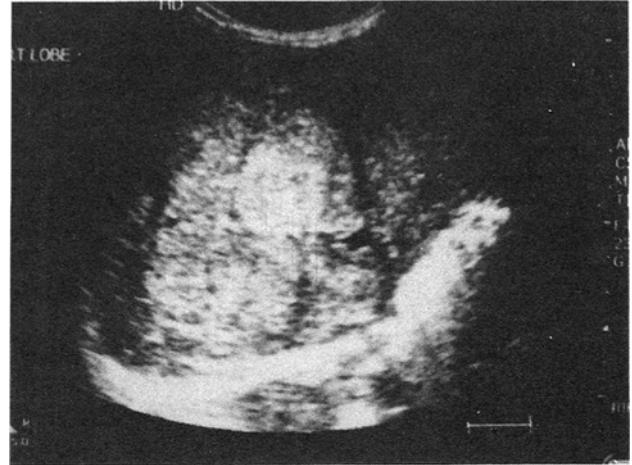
Longitudinal ultrasonogram shows predominantly hyperechoic heterogeneous echotexture of liver.
